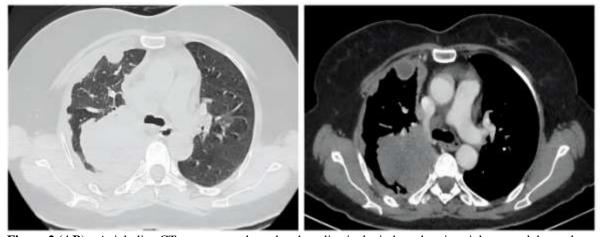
(AB):- Axial-slice CT scan, parenchymal and mediastinal window showing right upper lobar pulmonary lesional process, (green arrow).
